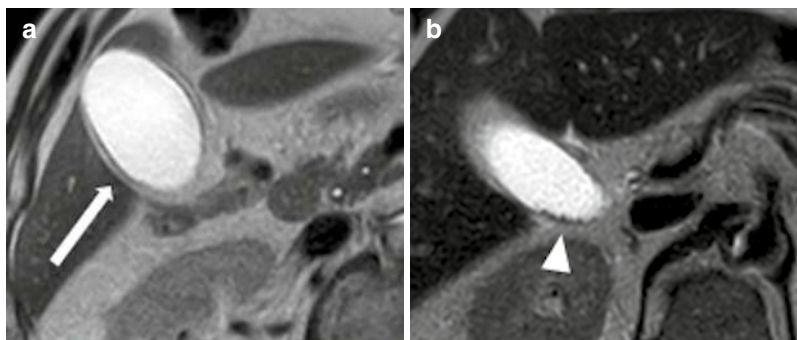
An 85-year-old man with acute cholecystitis caused by cystic duct obstruction due to an impacted calculus. MR imaging was performed because the cause of the suspected acute cholecystitis could not be determined
